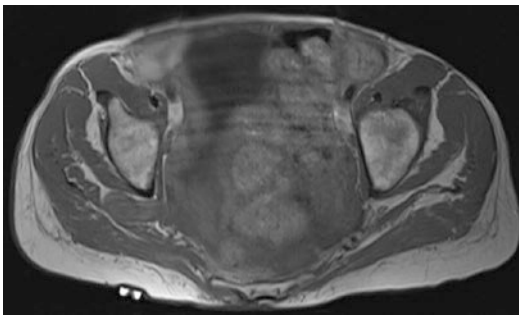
Right sciatic notch hernia with small intestine content, noted in a patient with complaint of sciatic pain and fullness, MRI pelvis axial view. Note the radioopaque marker over right upper buttock
